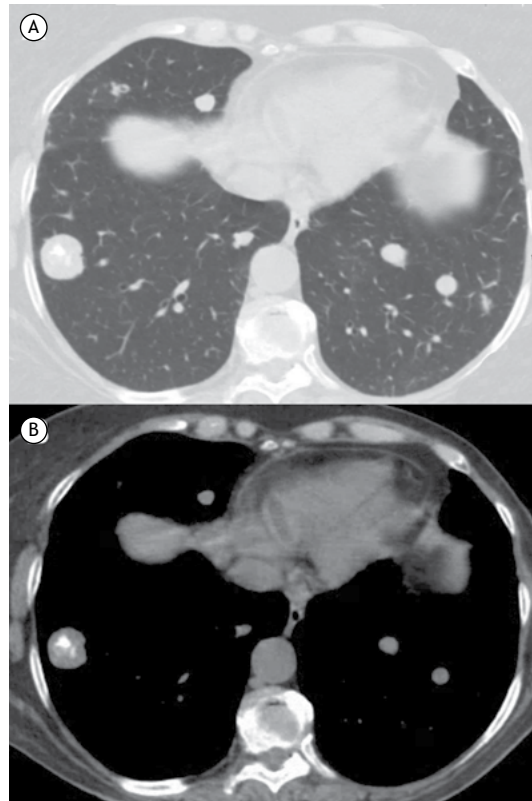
A 72-year-old woman with primary osteosarcoma of the femur. In A and B, CT scans showing multiple nodules of various sizes in both lungs, with the largest nodule being on the right side and showing inner calcification. The patient died 9 months after treatment initiation.
